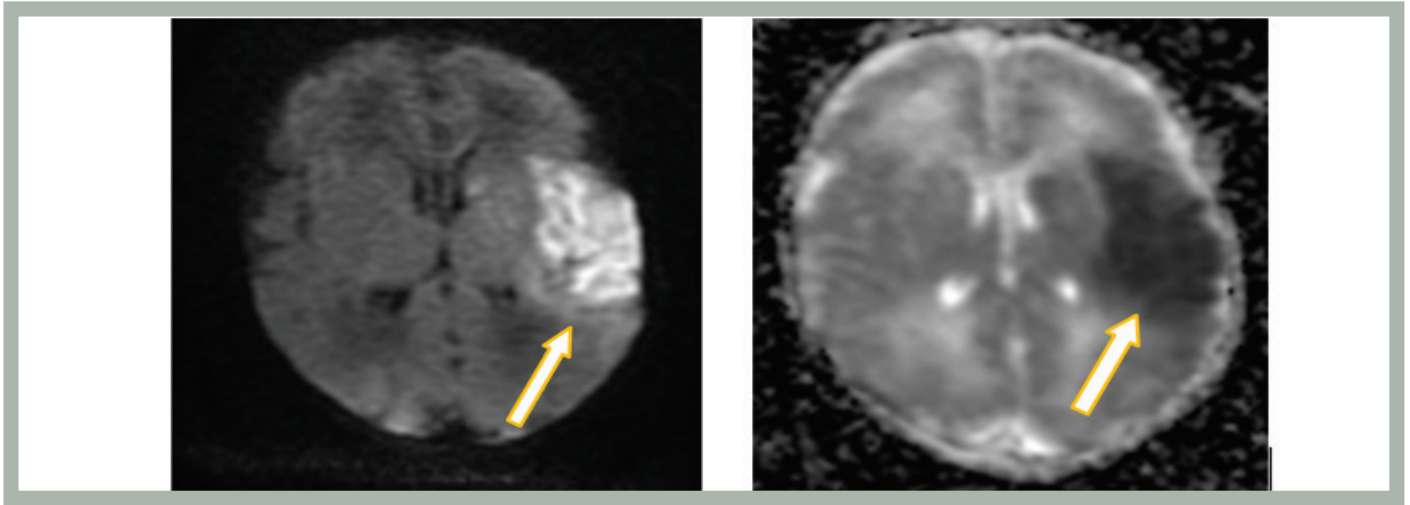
Diffusion-weighted magnetic resonance brain imaging axial section, showing extensive acute infarct areas in the posterior cerebral artery supply regions of the right temporo-occipital region, hyperintense on T2-weighted sequences, and hypointense signal change on T1-weighted sequences
